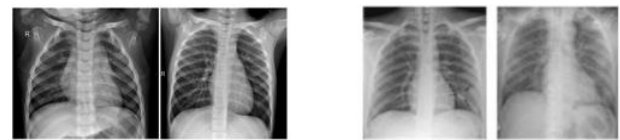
Chest X-Ray sample images: 'Normal' (left) and 'COVID-19' (right)
